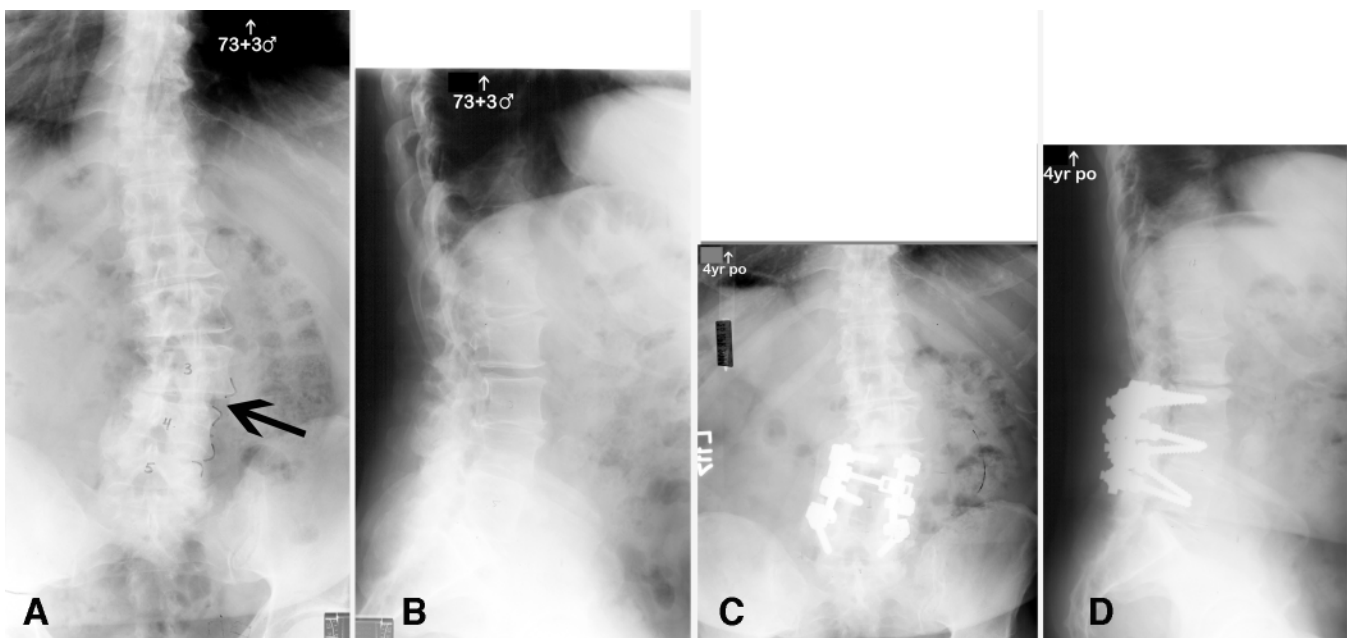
Lenke-Silva Treatment Level II. A and B: Radiographs obtained in a 73-year-old male, showing spinal stenosis from L-3 to L-5 and a rotary subluxation at L3–4. He was treated with decompression and a posterior spinal fusion from L-3 to L-5. C and D: At 4 years postoperatively, he had a solid fusion from L-3 to L-5 with slight disc degeneration at L2–3.
